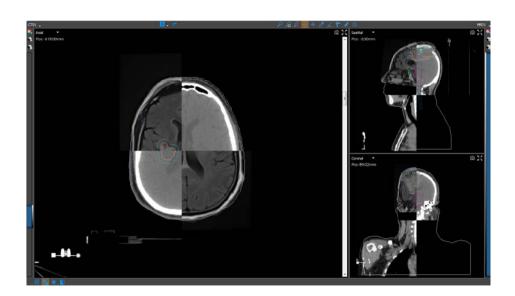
The delineation of a glioblastoma with MRI
